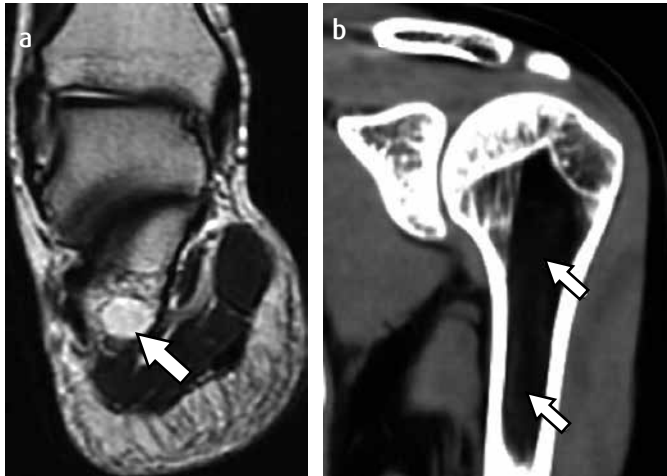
a) T1-weighted sagittal MRI sequence: high signal lesion, rounded, well defined, located in the bone marrow of the lateral portion of the calcaneum that due to its behaviour corresponds to intraosseous lipoma (arrow). b) CT with coronal reconstruction. One can identify a fat density lesion that is located in the proximal metaphysis-diaphyseal osseous marrow of the humerus, of defined contours, without periosteal reaction, corresponding to intraosseous lipoma (arrows).
